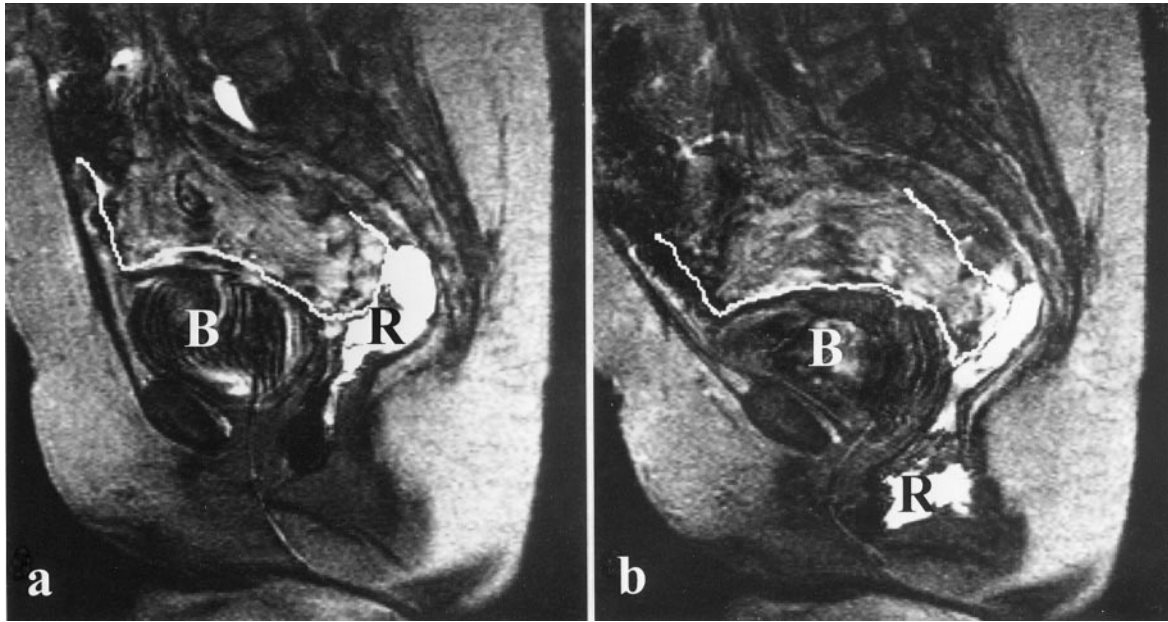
Sagittal MRI of the pelvis at rest (a) and during a Valsalva maneuver (b) in a 68-year-old patient with vaginal prolapse following abdominal hysterectomy in 1969. Extensive rectocele (R, opacification of the rectum), no enterocele and cystocele occurred during the Valsalva maneuver B, bladder.
